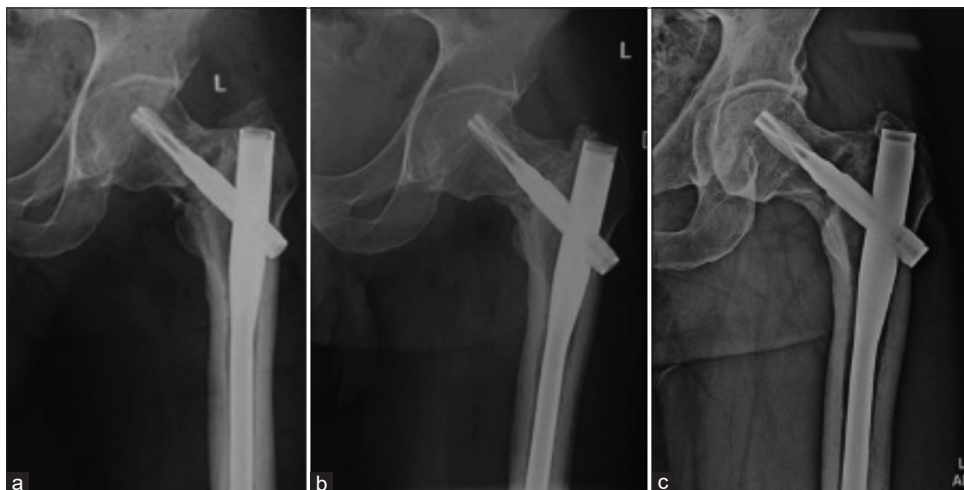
Plain radiograph (a) immediately after surgery showing the left neck femur fixation with PFNA II, (b) At 3 months showing fracture in process of union, (c) At 12 months showing united fracture
